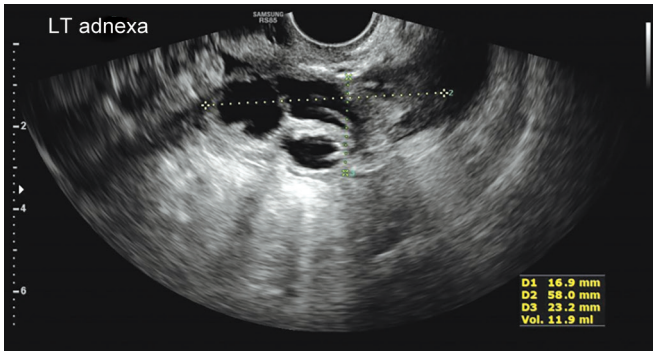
Pelvic ultrasound
